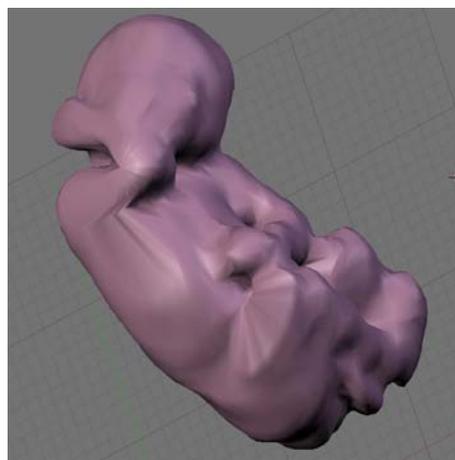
A 3D fetus shape, extracted from an MRI data set, after Gaussian smoothing
